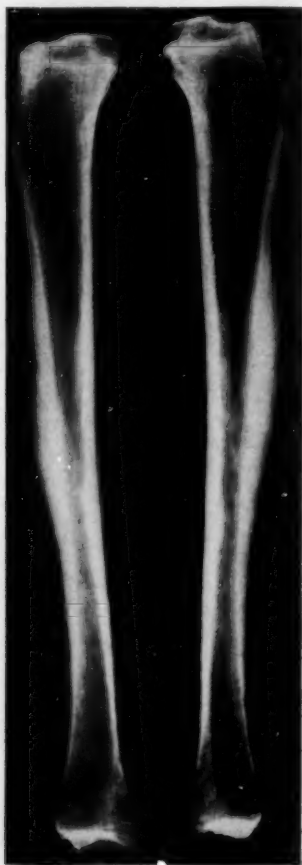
Roentgenogram of tibiae in case 4 from Ohio. This was made by Dr. E. C. König, Buffalo General Hospital.
